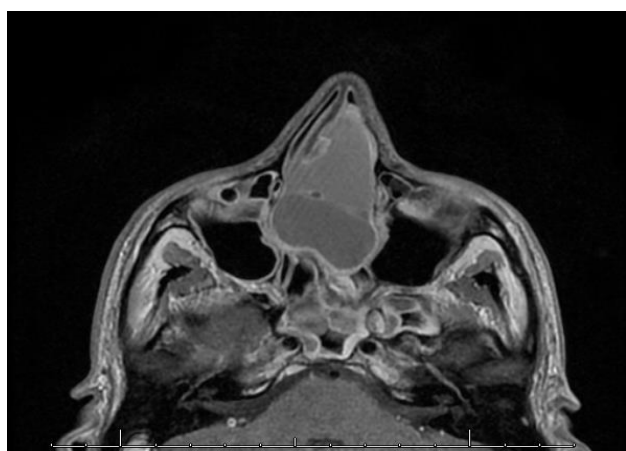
Magnetic resonance imaging axial view showing a mass within the nasal septum.
